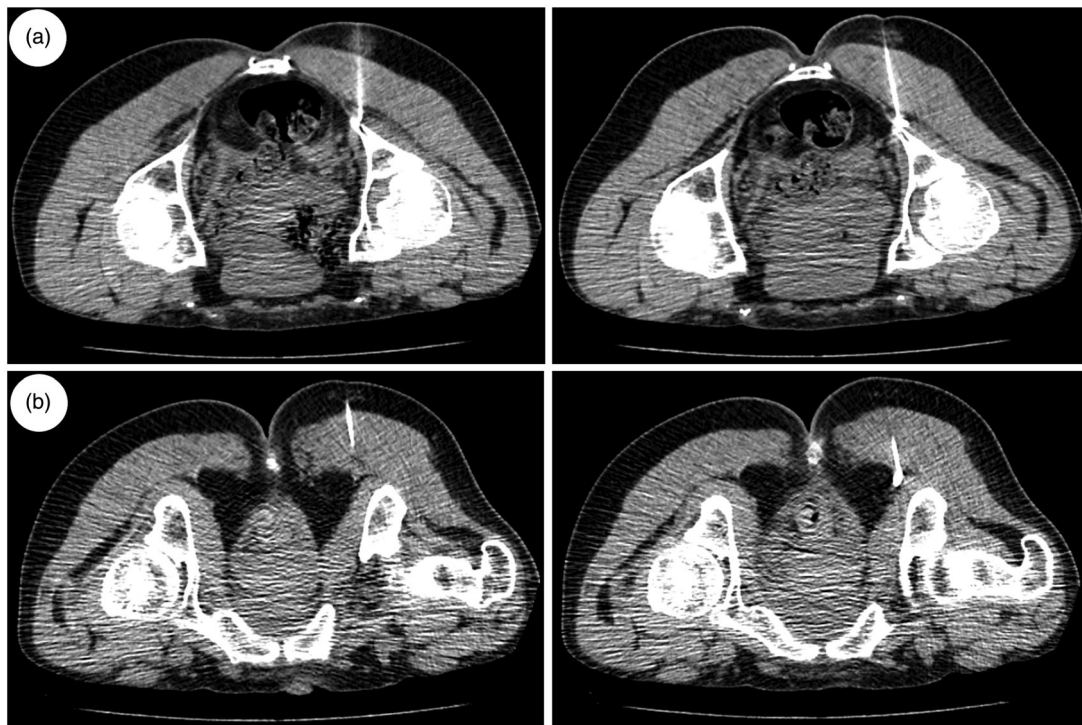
22-gauge needle inserted under computed tomography guidance: (a) at the level of the sacrospinous ligament and (b) at the level of Alcock's canal.
